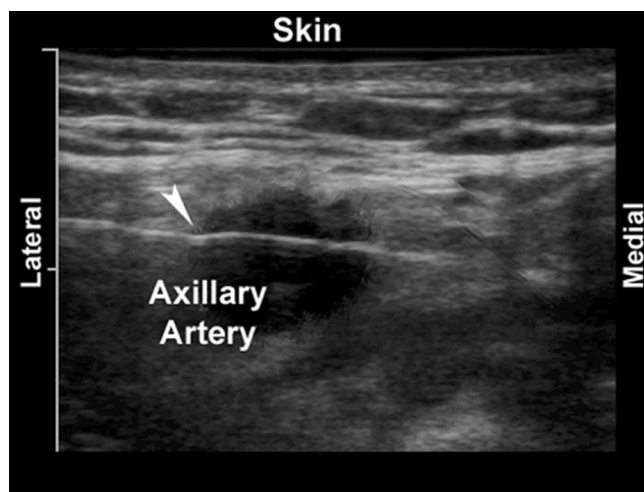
“Bayonet” bending of the needle shaft echo as the block needle passes through soft tissue and the axillary artery during an ultrasound-guided axillary nerve block. The arrowhead indicates the part of the needle echo that bends toward the ultrasound probe on the skin surface. Tick marks are 10 mm apart.
